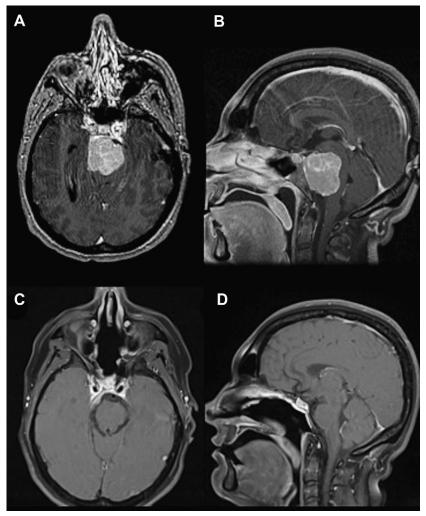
(A) Axial and (B) sagittal preoperative post contrast-enhanced T1-weighted magnetic resonance images showing a clival meningioma in a 32-year-old female patient. The lesion appears slightly enhanced after intravenous contrast injection and is located posterior to the clivus mostly on the midline. Dural attachment on the right tentorial edge can also be seen. (C) Axial and (D) sagittal postoperative magnetic resonance images after an endoscopic endonasal approach to the clival area, demonstrating the complete removal of the lesion.
